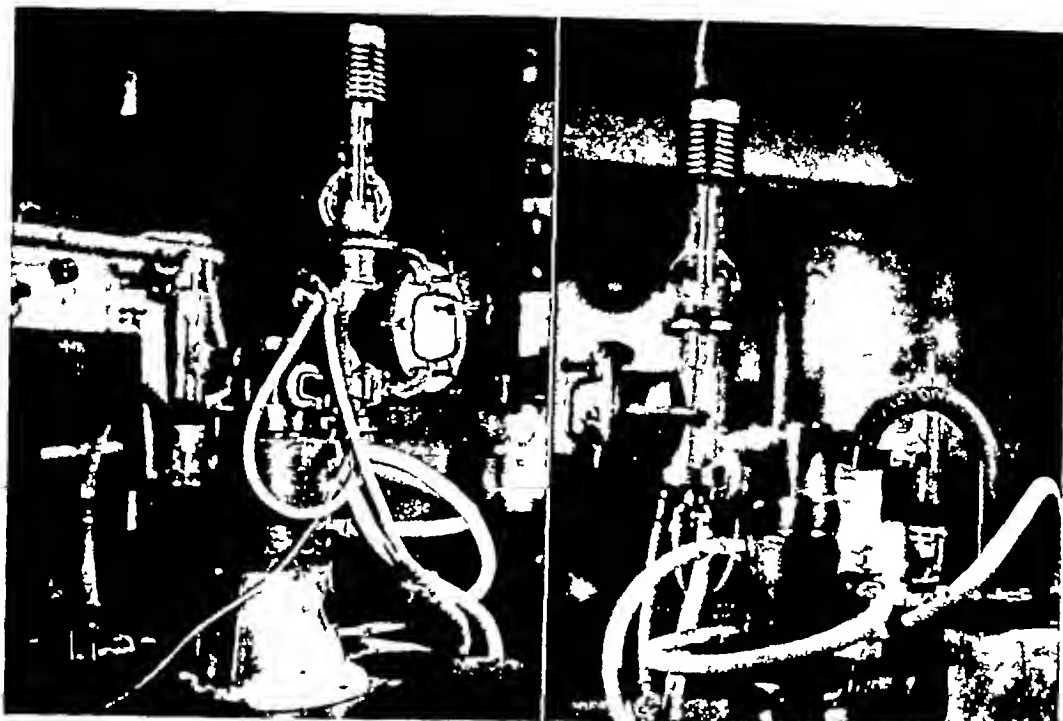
Pumping system (T) Tube, (A) Oil diffusion pump, (B) Mercury diffusion pump, (C) Tank for primary vacuum, (D) Air gauge, (F) Rotating oil pump, (J) Thermionic gauge, (T) X-ray tube
